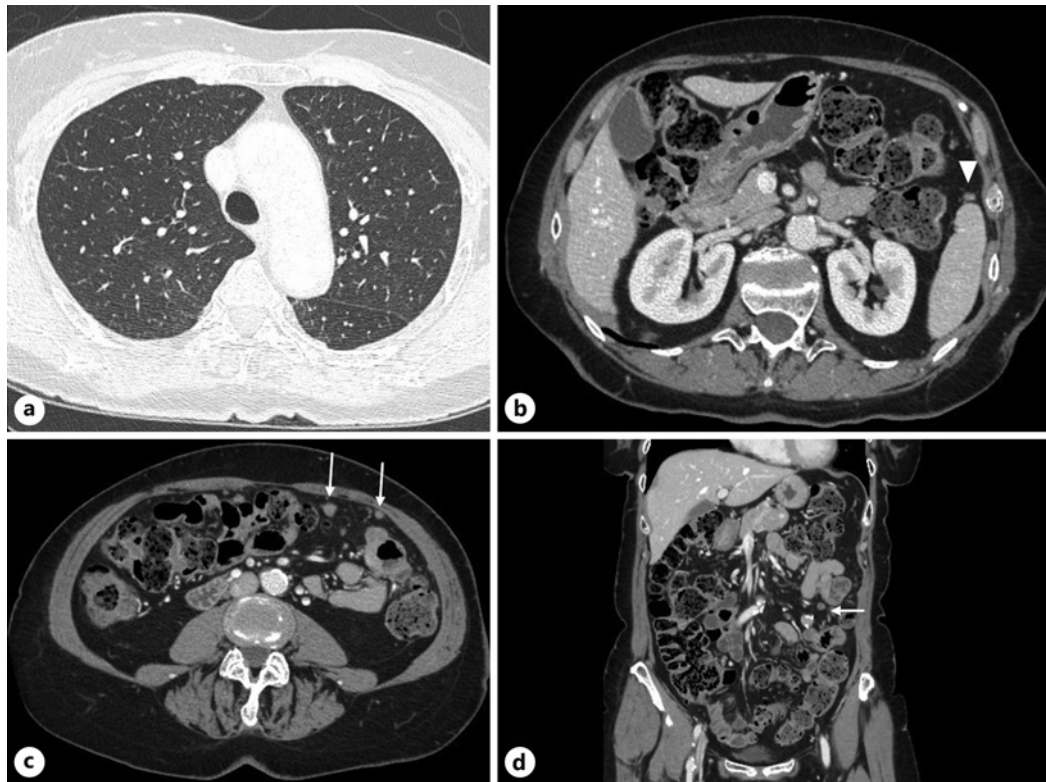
Third CT control 10 months after the start of immunotherapy. Volumetric CT MPR images in the axial (a–c) and coronal (d) planes after intravenous contrast media administration. a The pulmonary metastasis is no longer visible in the posterior segment of the upper lobe of the right lung. b–d Further reduction in size of peritoneal nodules (arrowhead) and omental masses are no longer present but only small and isolated nodules (white arrows) with restoration of omental and mesenteric fat density.
